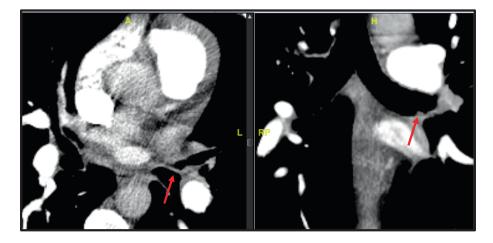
Axial sections of the CT thorax and corresponding coronal images reveal a small arterial branch coursing (red arrow) along the submucosal surface of the left upper and lower lobe bronchi. CT, computed tomography.
